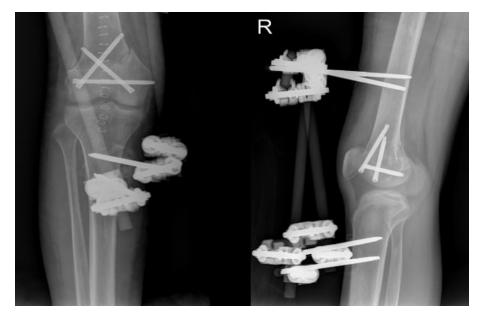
Early postoperative X-rays.
